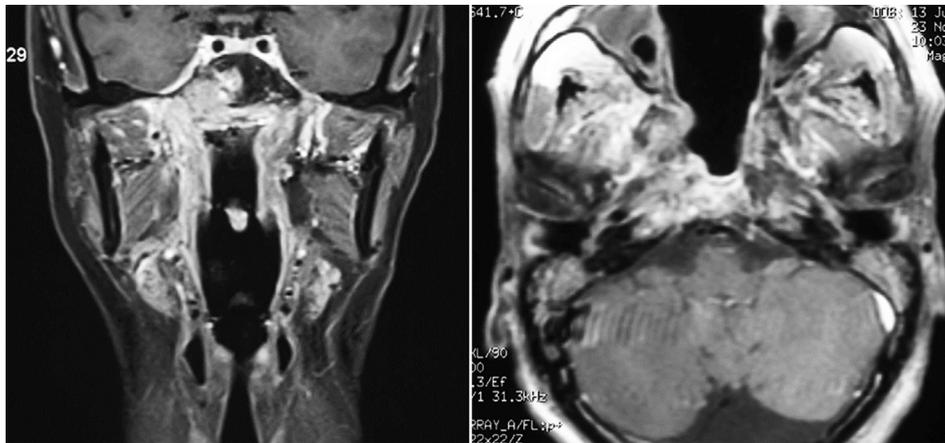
(Left) Coronal view of MRI showing recurrent NPC involving the lateral wall of the right sphenoid sinus abutting the septum. (Right) Axial cut of another patient with recurrent NPC invading both the anterior and posterior cortex of the clivus.
